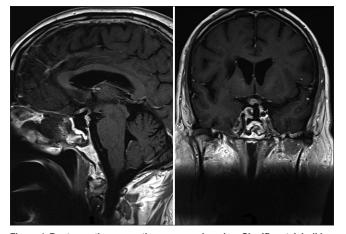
Postoperative magnetic resonance imaging: Significant debulking and well-decompressed optic apparatus. The small non-compressive residual tumor was addressed with adjuvant fractionated radiotherapy
